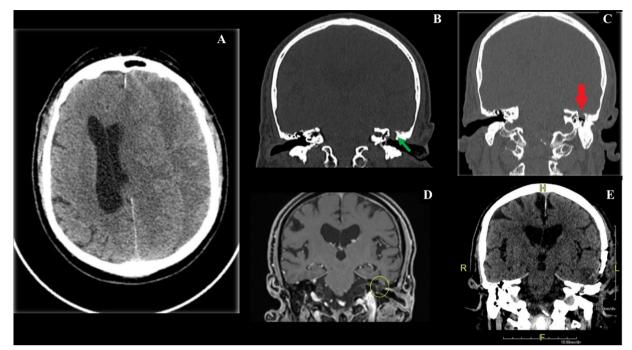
A The patient following cognitive impairment and right sensorimotor neurological deficit underwent an initial cranial CT scan documenting large CSDH and subsequently underwent evacuation surgery by craniotomy hole. After four months, patient started to suffer from otorrhea of the left ear. A high-resolution CT scan (HRCT) evidenced the presence of phlogistic tissue in the left tympanic cavity and mastoid antrum with tegmen tympani erosion and a skull-base significant defect (B, C, red and green dot). A brain MRI was performed and confirmed the presence of a temporal ME through the skull base defect (D). The patient underwent surgical repair with a subtemporal approach, and the herniation site was repaired with muscle, heterologous dural patch, and fibrin glue. Postoperative follow-up HCT documented a successful procedure without complications (E)
